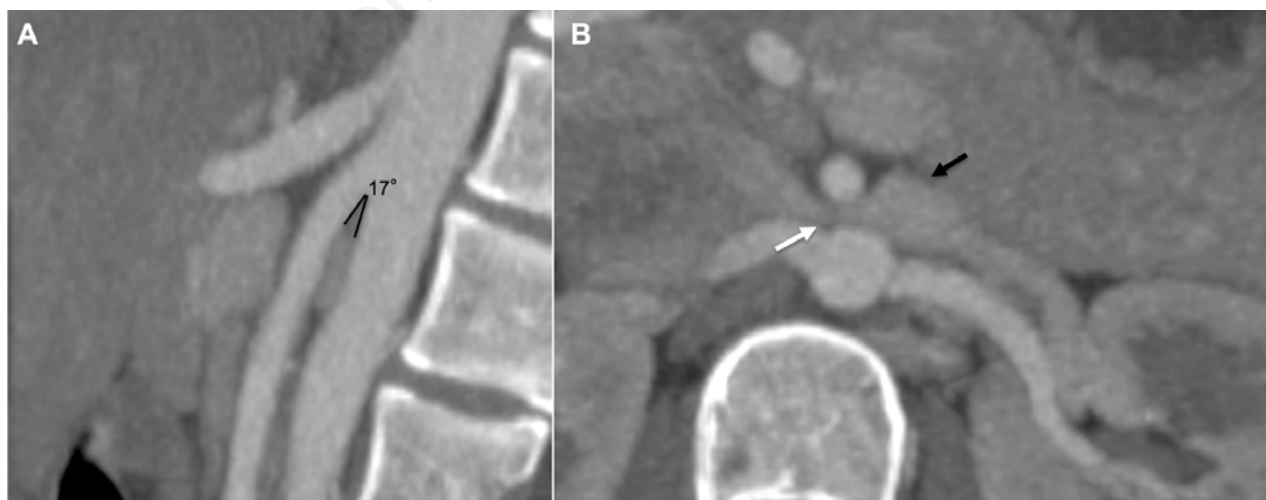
Preoperative computed tomographic angiography showing A) the small aorto-mesenteric angle (17°) between Superior Mesenteric Artery (SMA) and abdominal aorta B) that compress the left renal vein (white arrow) with a consequent pre-stenotic dilatation (black arrow).
